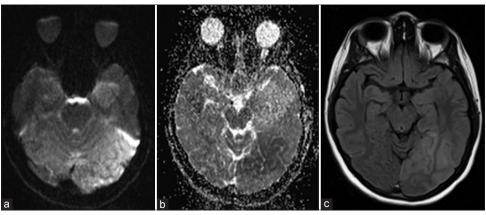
(a) Diffusion MRI (b) ADC Map (c) FLAIR sequence
